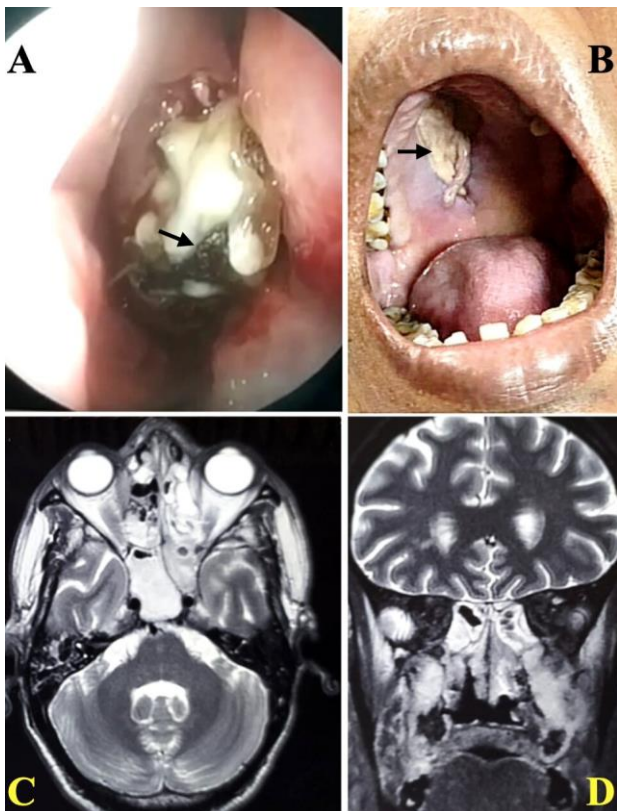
(A) Diagnostic nasal endoscopy image showing classical black eschar of the middle turbinate (black arrow); (B) necrotic tissue (black arrow) seen involving the hard palate; MRI of the brain with paranasal sinuses- (C) axial view; and (D) coronal view showing extensive involvement of the paranasal sinuses in a case of post coronavirus disease mucormycosis.
